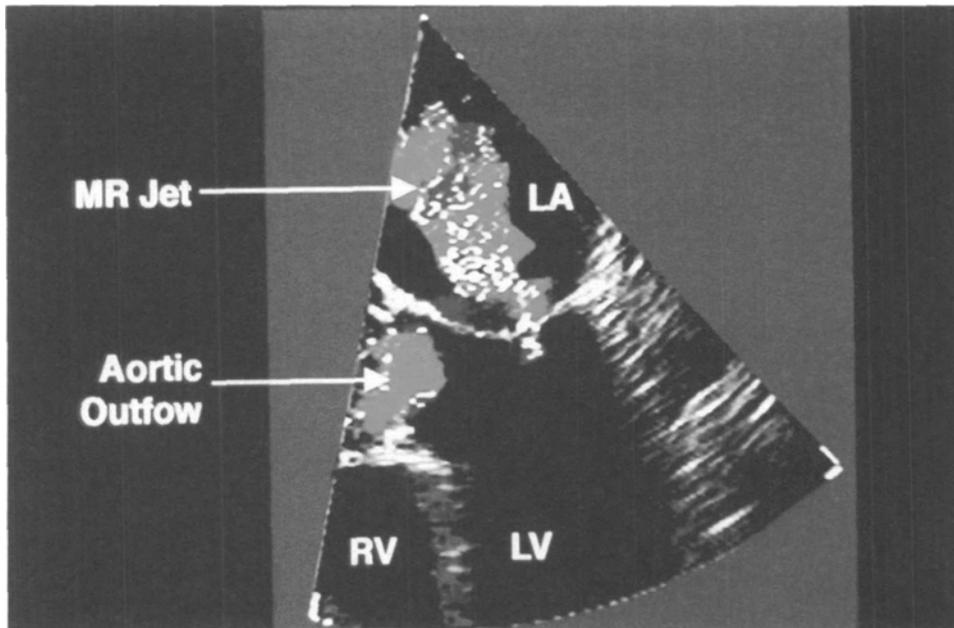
Mitral regurgitation. With colour Doppler applied to the three chamber view in systole, a regurgitant jet is seen in the left atrium. Also appreciated is normal systolic flow in the LVOT. The area of the regurgitant jet is 7.2 cm², which is consistent with severe mitral regurgitation.^{41,42}
